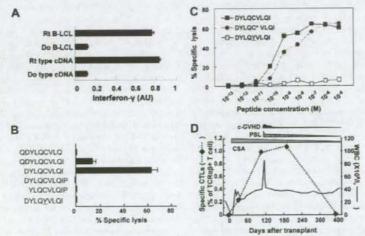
Identification of the CTL-189 minimal minor H epitope. (A) Interferon-y production from CTL-189 against HLA-A-2402-transduced 293T cells transfected with plasmid encoding full-length BCL2A1 cDNA cloned from either the recipient (Rt) from whom CTL-189 was isolated or his donor (Do). Rt B-LCL and Do B-LCL were used as positive and negative controls, respectively. Secreted interferon-y was measured by ELISA and is expressed in arbitrary units (AUs) corresponding to optical density at 630 nm. Results are typical of 2 experiments and data are the mean plus or minus SD of triplicates. (B) A peptide reconstitution assay was conducted to determine the minimal epitope for CTL-1B9. Nonameric peptide (DYLQCVLQI), 2 nonameric peptides shifted by one amino acid to N- or C-terminus, N- and C-terminal extended decameric peptides, and its allelic counterpart (DYLQYYLQI) were synthesized and tested by adding to antigen-negative donor B-LCL at 10 nM in a standard 51Cr release assay. Results are typical of 2 experiments and data are the mean plus or minus SD of triplicates. (C) Titration of the candidate minor H peptide by epitope reconstitution assay. Chromium-labeled donor B-LCLs were distributed to wells of 96-well round-bottomed plates, pulsed with serial dilutions of the indicated peptides for 30 minutes at room temperature, and then used as targets for CTL-189 in a standard \$^Cr release assay. A cysteinylated peptide (indicated by an asterisk) was included as an atternative form of the potential epitope. Results are Typical of 2 experiments. (D) Tracking of ACC-1C-specific T cells in the recipient's peripheral blood. In order to longitudinally analyze the kinetics of the ACC-1C-specific CTLs in peripheral blood from the patient from whom CTL-189 was established, a real-time quantitative PCR was conducted. Complementary DNAs of peripheral blood mononuclear cells from the donor and patient before and after HSCT were prepared from the patient. Real-time PCR analysis was performed using a TaqMan assay as described previously. The primers and fluorogenic probe sequences spanning the CTL-189 complementarity-determining region 3 (CDR3) were used to detect T cells carrying the CDR3 sequences identical to that of CTL-189. The primers and fluorogenic probe sequences spanning constant region of TCR beta chain (TCRBC) mRNA were used as internal control. Samples were quantified with the comparative CT method. The delta CT value was determined by subtracting the average CT value for TCRBC from the average CTL-189 CDR3 CT value. The standard curve for the proportion of CTL-189 among TCRap* T cells was composed by plotting mean delta CT values for each ratio, and the percentages of T cells carrying the CDR3 sequence identical to CTL-189 were calculated by using this standard curve. During this period, quiescent chronic GVHD, which required steroid freatment, developed; however, involvement of immune reaction to ACC-10 minor H antigen was unlikely since its frequency increased even after resolution of most chronic GVHD symptoms. c-GVHD, chronic GVHD; CSA, cyclosporine A; PSL, prednisolone; WBC, white blood cell count.
